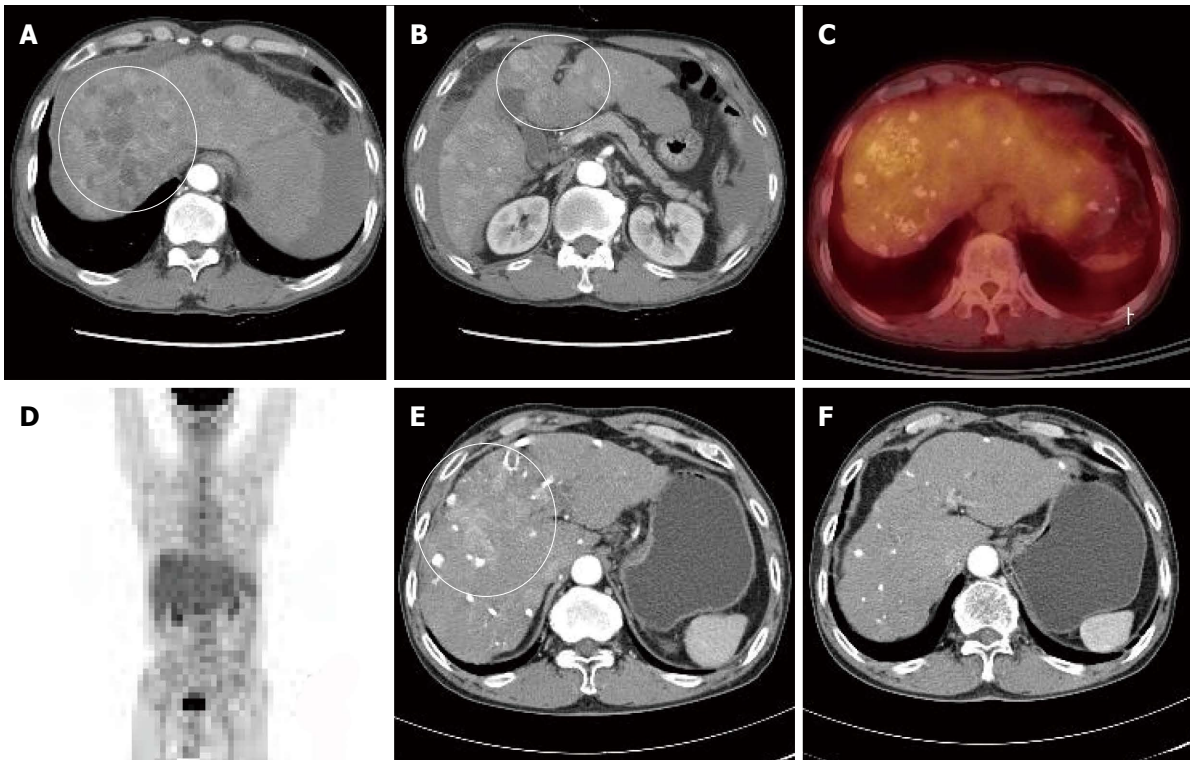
Computed tomography of the patient. A, B: Computed tomography (CT) scan taken at the time of hepatocellular carcinoma (HCC) diagnosis showing intrahepatic multinodular HCCs (white circles); C, D: Positron emission tomography CT scan showing multiple lipiodolized masses and abnormal fluorine-18 2-fluoro-2-deoxy-*D*-glucose uptake on liver (no distant metastasis was found); E, F: After repetitive transarterial chemoembolization, a viable hypervascular mass remained (E, white circle), but after 6 mo of oral sorafenib, this was not detected by liver dynamic CT (F, arterial phase).
